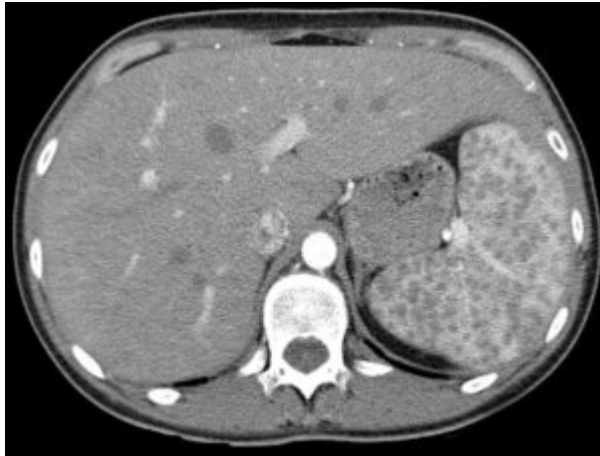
"Sarkoidose der Milz CT axial" by Hellerhoff. License: [CC BY-SA 3.0](#)
